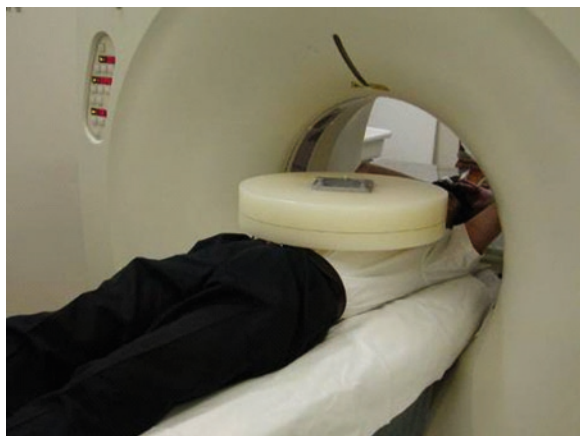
CT scanner experiment
